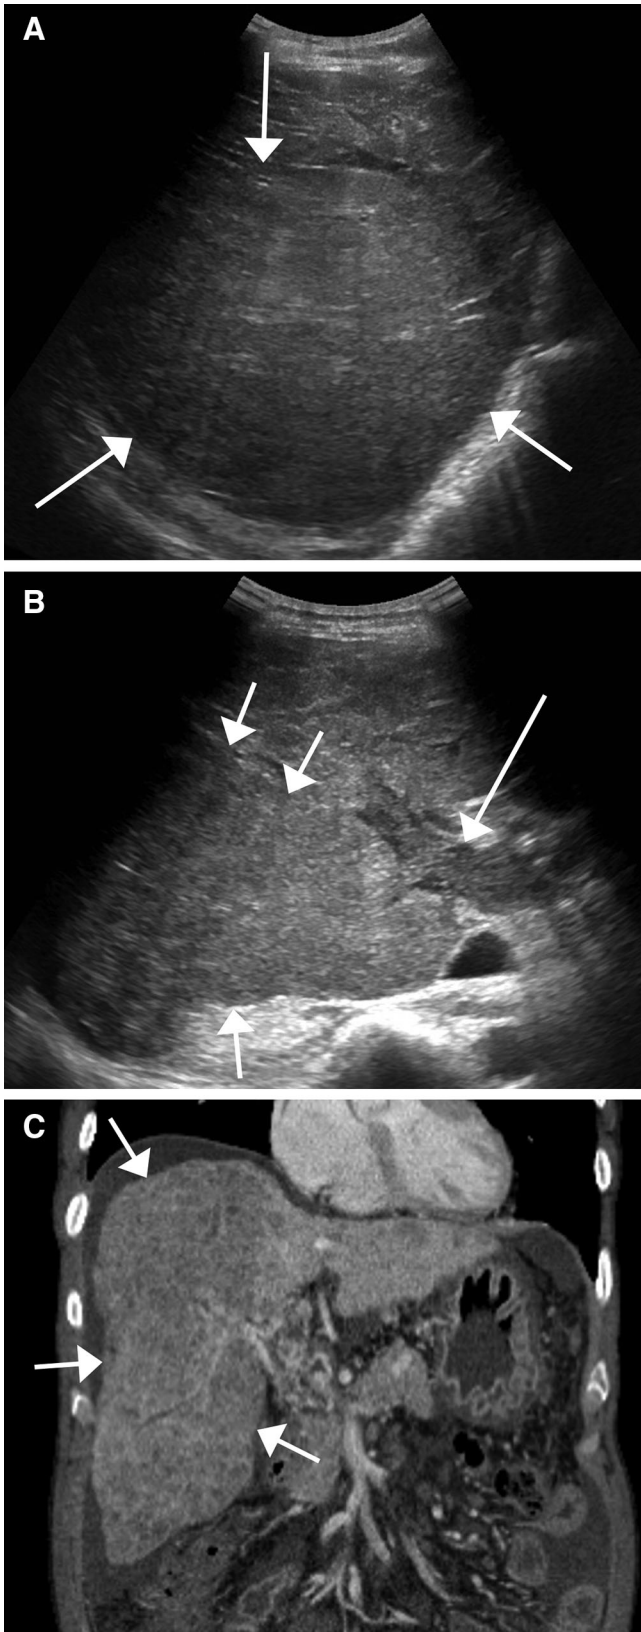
LI-RADS US-3: positive. A 67-year-old male with cirrhosis secondary to hepatitis C. A Grayscale ultrasound image shows focal geographic heterogeneity with refractive edge shadowing (*arrows*). B Contrast-enhanced CT confirmed large infiltrative HCC (*arrows*) corresponding to focal ultrasound abnormality (images reproduced with permission by the ACR).
